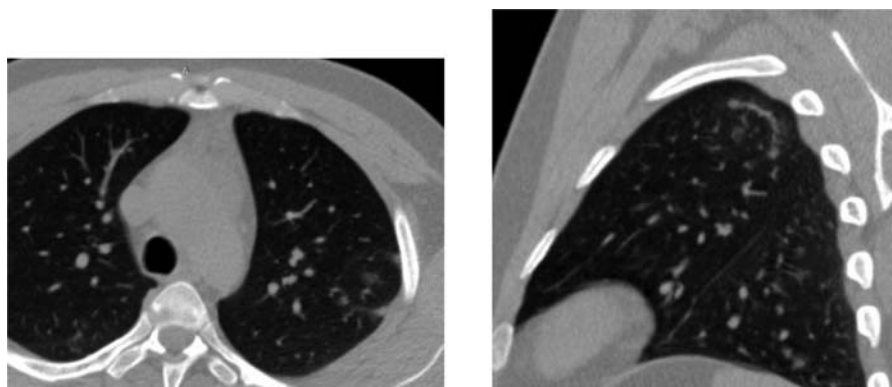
Sagittal reformatted chest CT scan image in a 38-year-old male patient with COVID-19 pneumonia showing the simultaneous presence of reversed halo sign (yellow arrow) and the bullseye sign (red arrow).
